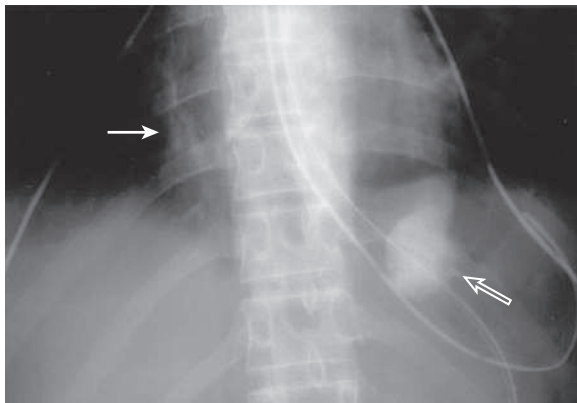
Chest radiograph taken in the emergency department, showing sand bronchograms in the right lower lobe (solid arrow). Note sand within the gastric fundus (open arrow). (From Dunagan DP, Cox JE, Chang MC, et al: Sand aspiration with near-drowning: radiographic and bronchoscopic findings, Am J Respir Crit Care Med 156:292, 1997.)
